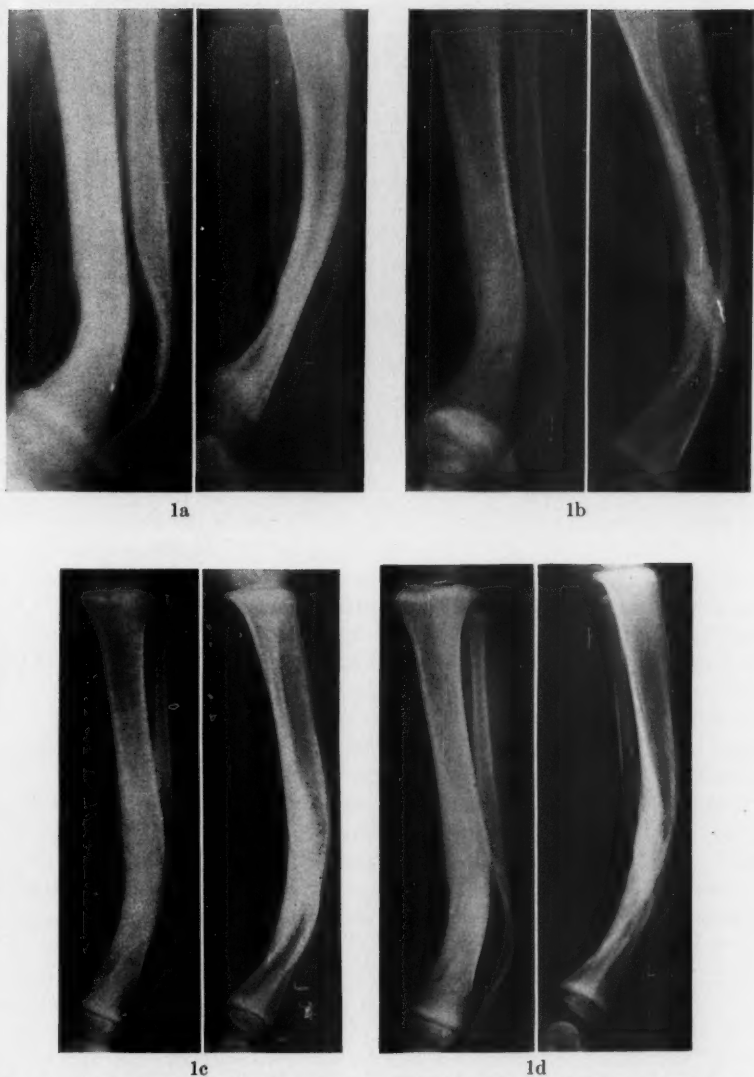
Roentgenograms Nov. 24, 1948. Compound bowing of the tibia and fibula at the junction of the middle and distal thirds. Note the constriction at the site of bowing and the absence of sclerosis at the site of bowing.
